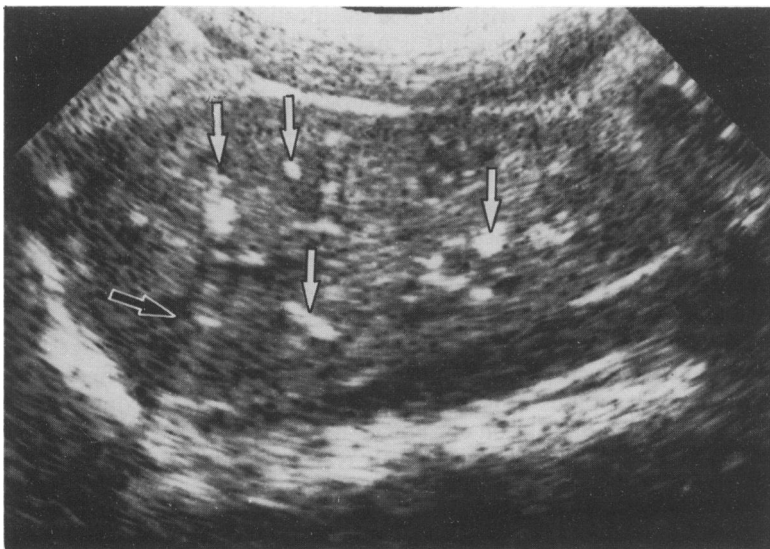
Ultrasound scan of a neonatal kidney demonstrating hyperechogenic renal pyramids (white arrows) with accompanying acoustic shadowing (black arrow). This patient was not treated with frusemide.
